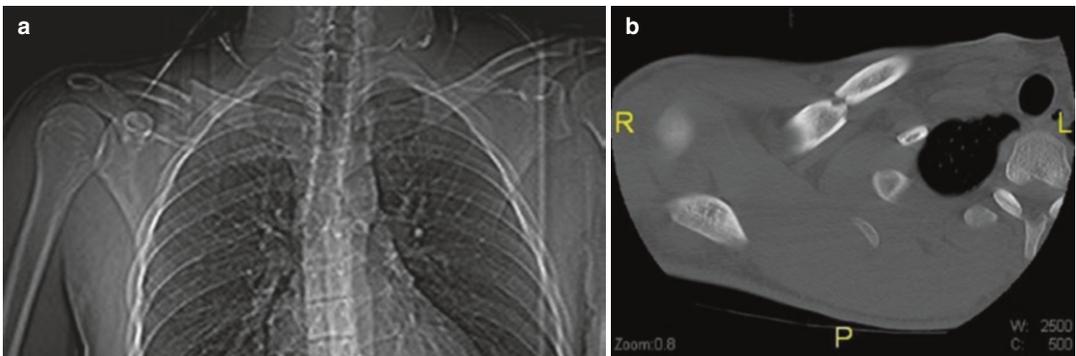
(a, b) CT demonstrates the fracture malrotation in same patient in Figs. 8.4 and 8.5
